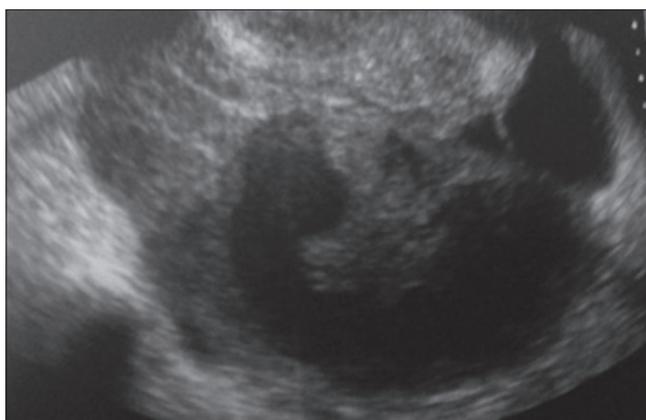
Transvaginal sonography showing dilated tubular tortuous structure in adnexa with echoes within suggestive of pyosalpinx
